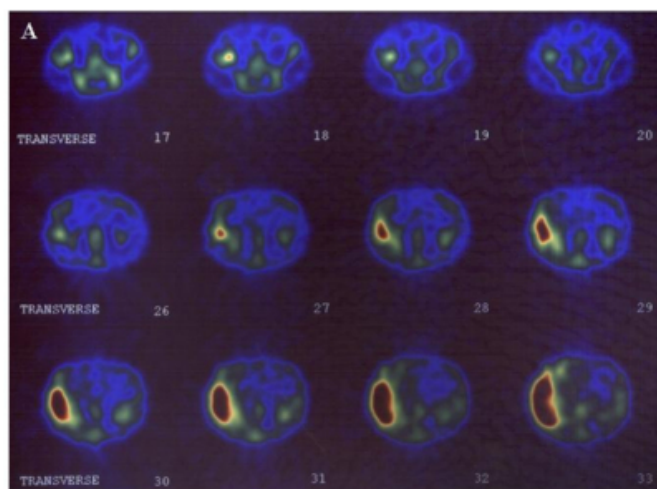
SPECT of the Ga-67 scan. The arrow show focal increased uptake.
